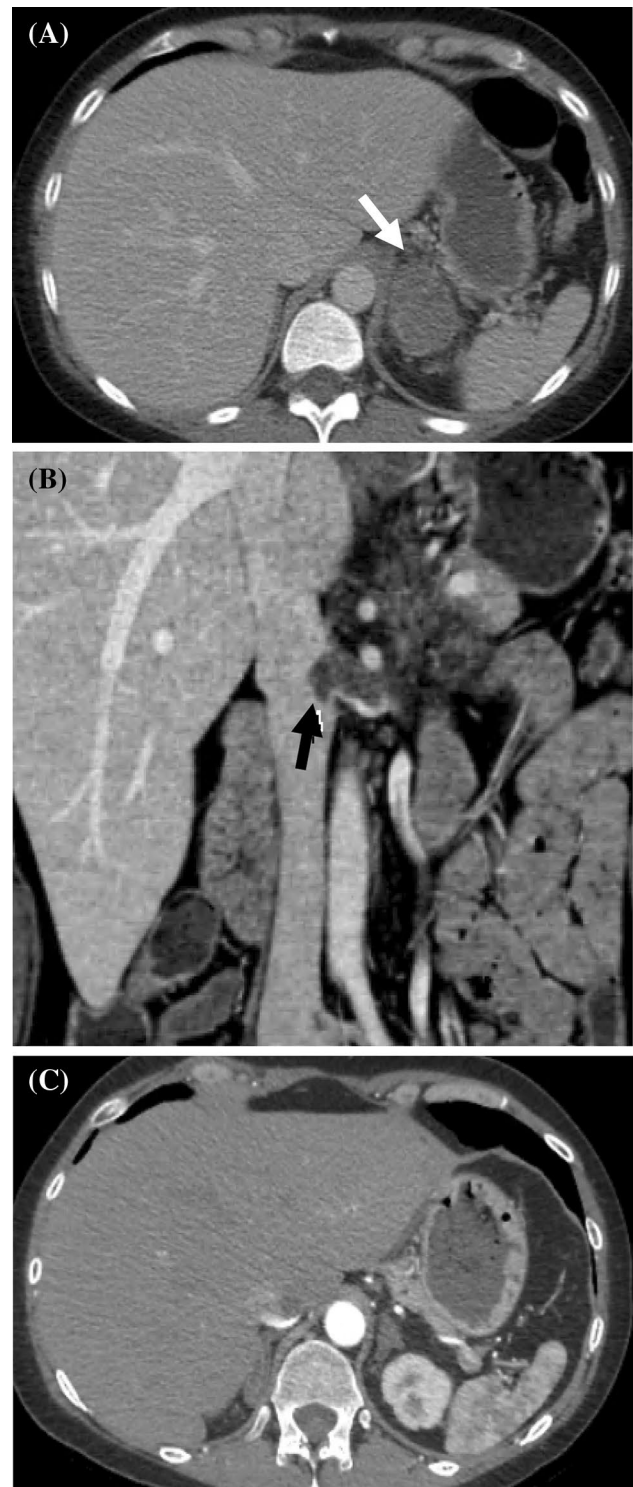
A 50-year-old female patient with left flank pain. a Axial contrast-enhanced abdominal CT shows a left non-enhancing adrenal mass (white arrow). b Coronal contrast-enhanced abdominal CT shows left renal vein occlusive thrombus (black arrow). c Follow-up abdominal CT obtained 3 months later shows complete resolution of the previously noted left adrenal mass, consistent with adrenal hematoma
